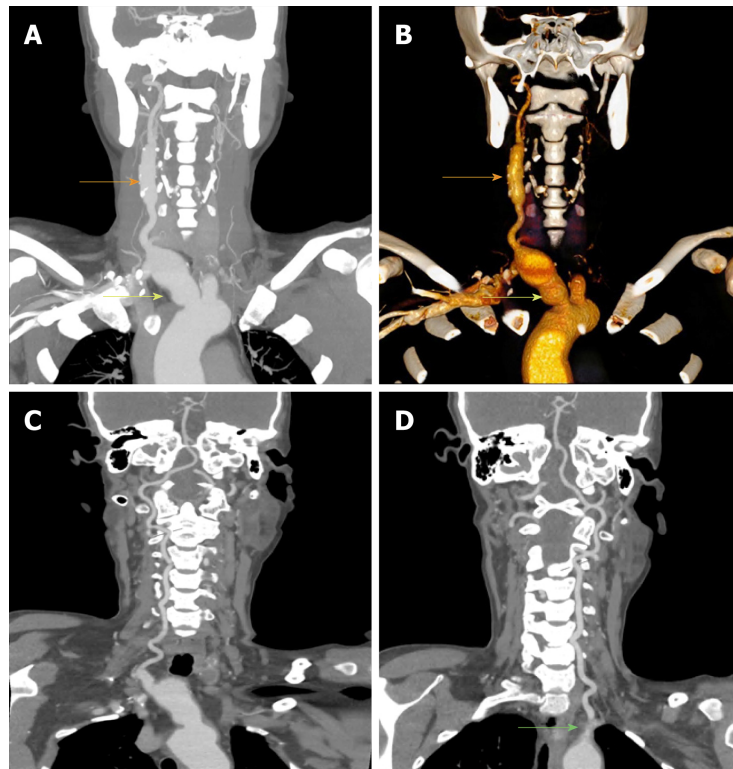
Preoperative computed tomography angiography of the patient. A and B: Innominate (yellow arrow) and right common carotid (orange arrow) arterial aneurysms and no display of the left carotid and subclavian arteries; C: Patency of the right vertebral artery; D: Occlusion of the initial part of the left vertebral artery (green arrow).
